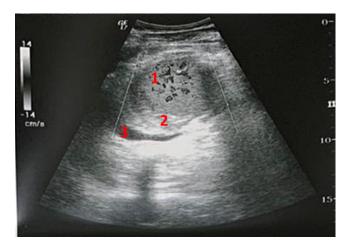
B mode ultrasound showed a rounded echogenic formation with subcapsular inhomogeneity and anechoic layer around it. This finding was suggestive for hypertrophic accessory spleen (1) with subcapsular hematoma (2) and hemoperitoneum (3).
